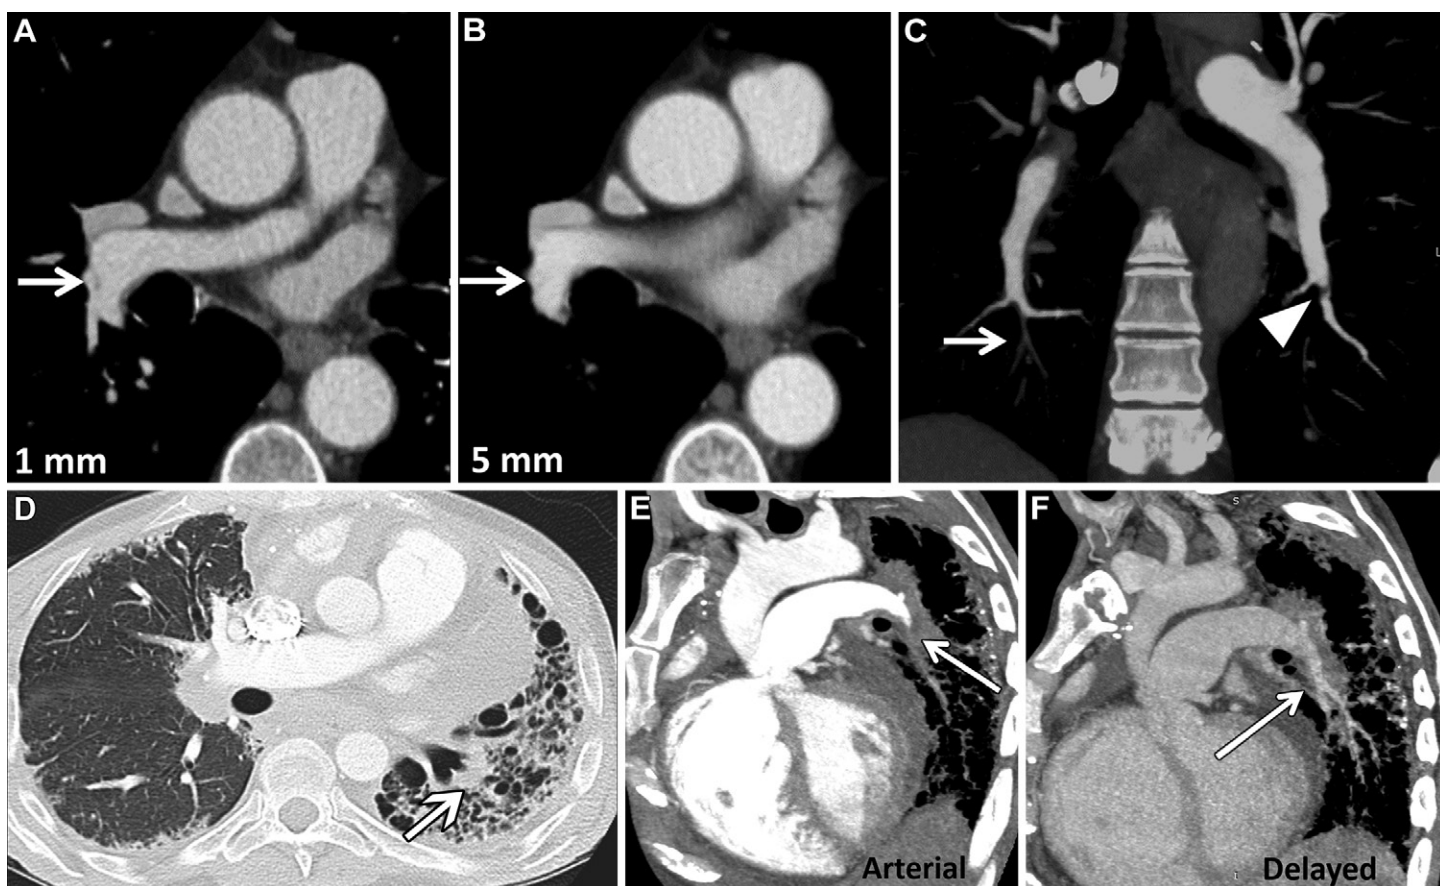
Reasons for misdiagnosis of CTEPD and CTEPH. (A, B) There are numerous technical factors that can lead to false-negative interpretations in patients with CTEPD. Axial CTPA image with 1-mm section thickness (A) shows a subtle band (arrow in A) in the right lower lobe. On an axial CTPA image with 5-mm section thickness (B), the band (arrow in B) is invisible owing to partial volume averaging. Given the subtlety of the findings, we recommend using a section thickness of 1 mm or less to interpret these studies. (C) Isolated segmental and subsegmental disease in patients with CTEPH is common and may be missed owing to lack of radiologist knowledge of some of the subtle imaging findings. Coronal CTPA image shows extensive but inconspicuous occlusive (arrow) and nonocclusive (arrowhead) disease in the segmental and subsegmental vasculature, leading to severe pulmonary hypertension. However, the outside CT study was interpreted as normal. (D–F) In addition to disease being missed, disease can be overcalled in certain situations. Axial CT image of the lungs (D) shows asymmetric usual interstitial pneumonia (arrow in D). Sagittal CTPA image (E) shows lack of filling of the left lower lobe pulmonary artery branches (arrow in E), which was misinterpreted as chronic clot on multiple occasions. On review, this finding was recognized as likely being related to slow flow from pulmonary fibrosis. On the basis of this suspicion, the patient was brought back for repeat imaging, which was performed with a 60-second delay. Sagittal CTPA image (F) from repeat imaging with a 60-second delay shows that the pulmonary artery opacifies normally (arrow in F).
